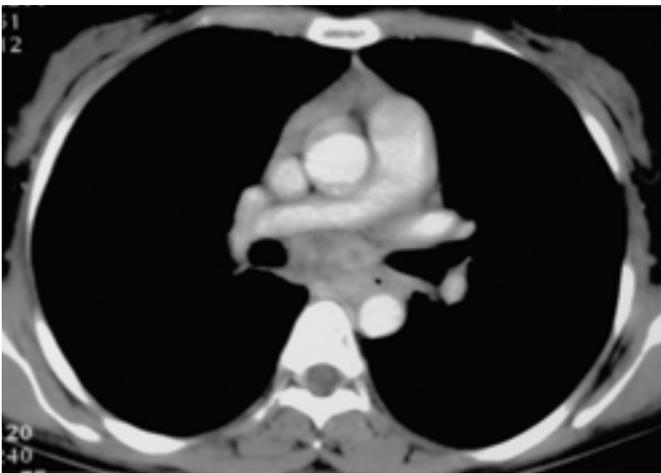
Esophageal perforation due to esophageal carcinoma in a 64-year-old man. CT was performed after esophagography. Leaked barium was shown as high-attenuation in right lower lobe on CT scans.
